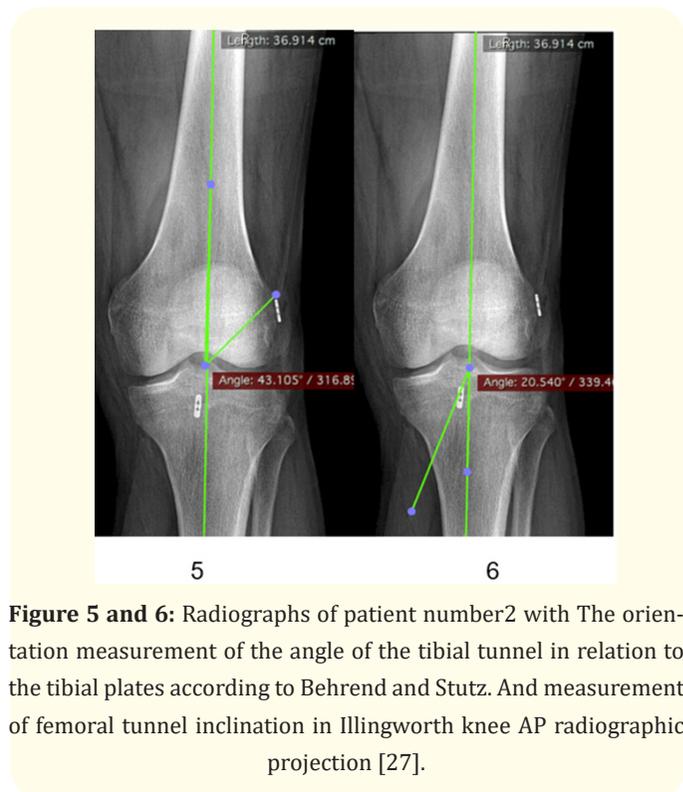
Radiographs of patient number 2 with The orientation measurement of the angle of the tibial tunnel in relation to the tibial plates according to Behrend and Stutz. And measurement of femoral tunnel inclination in Illingworth knee AP radiographic projection [27].
